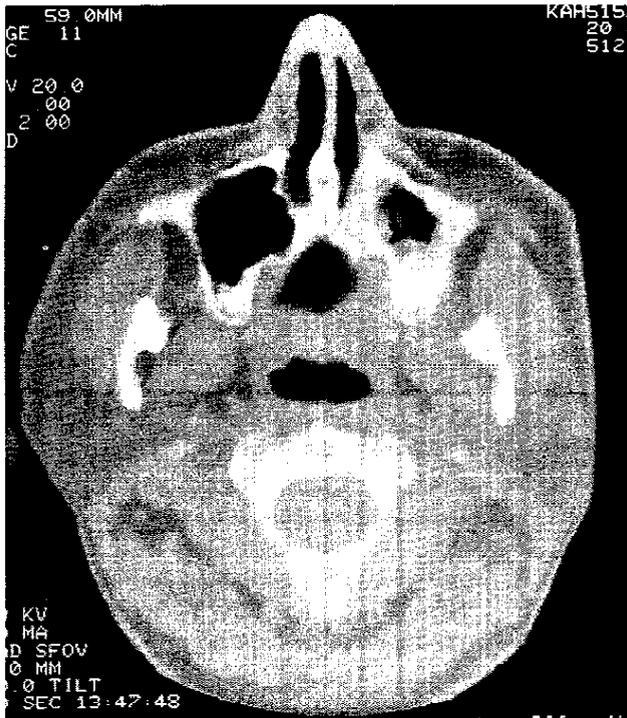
A CT scan showing a tooth in the nasal septum.
